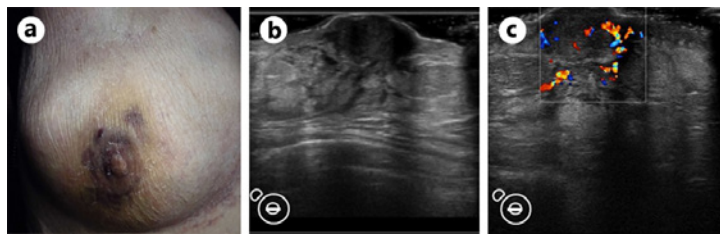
Physical and ultrasonography findings. a Physical examination during the patient's visit revealed an elevated lesion with blue purpura around the nipple in the right breast. b We performed breast ultrasound and detected a well-defined 19.6 × 16.4 × 10.7 mm hypoechoic tumor in the left subareolar area. c Blood flow rich.
